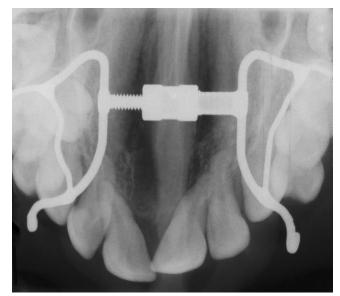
Case report 1: anterior occlusal radiograph, post-RME
